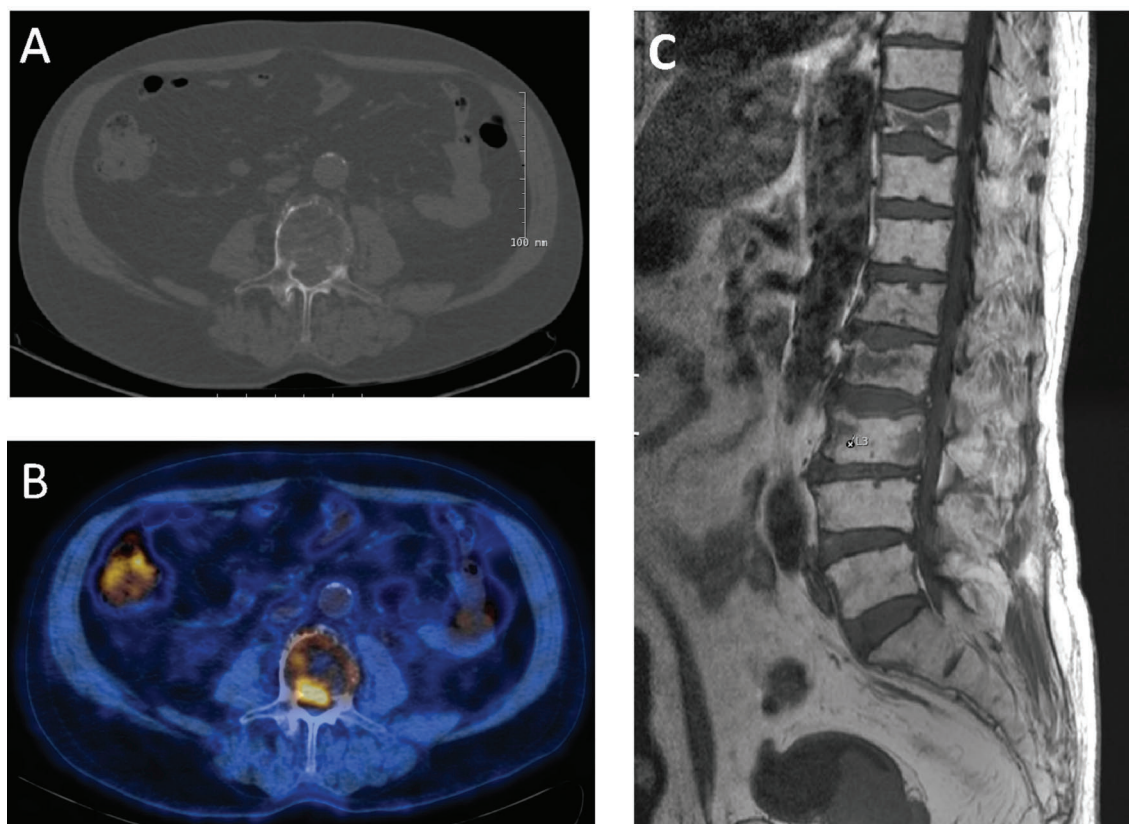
Imminent medullary compression revealed by low-dose CT. The low-dose CT-scan reveals tumor growth in the vertebral canal (A). This lesion was PET-positive (B). MR-scan confirmed the intra-spinal growth (C). The patient was asymptomatic.
